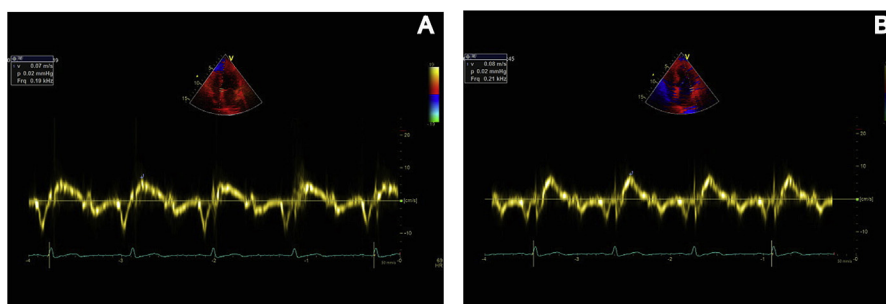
Pulsed tissue Doppler imaging from the (A) septal and (B) lateral mitral annuli in a chronic kidney disease patient.
